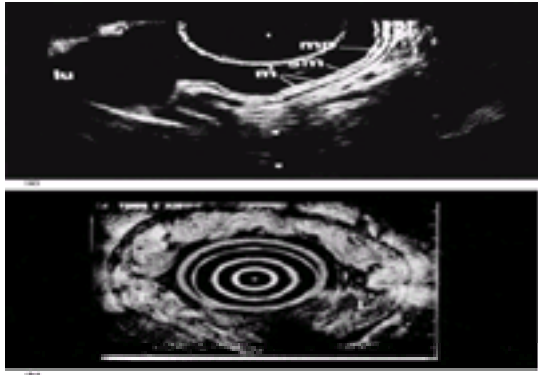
(a) Layers of the bowel lumen as seen during endoscopic ultrasound. M, mucosal layer; SM, submucosal layer; and MP, muscularis propria layer. (b) An esophageal tumor is seen invading all wall layers.
